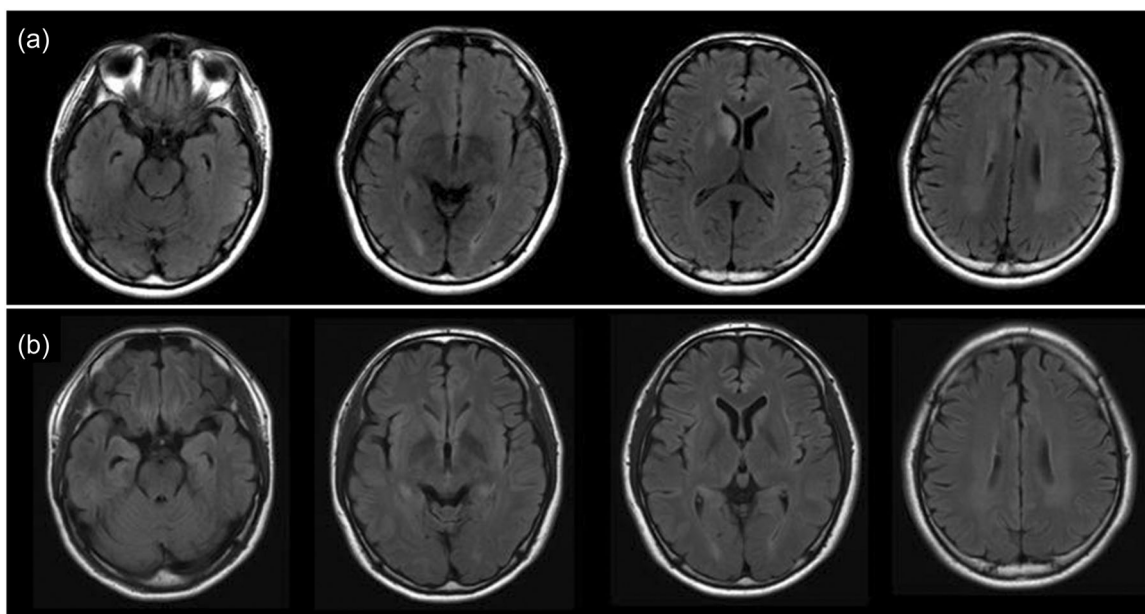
Neuroradiological findings. (a) Fluid-attenuated inversion recovery magnetic resonance imaging reveals swelling and hyperintensity in the right caudate nucleus and putamen. (b) The abnormal findings have resolved after methylprednisolone pulse therapy.
